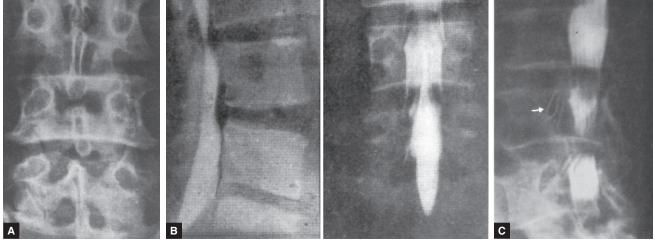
to C: (A) Plain X-ray showing bulbous spinous processes, obliteration of interlaminar space and coronal orientation of facets in spinal stenosis; (B) Myelogram showing hour glass defect due to facet hypertrophy without any evidence of disc prolapse; (C) Myelogram showing multiple spinal stenosis
